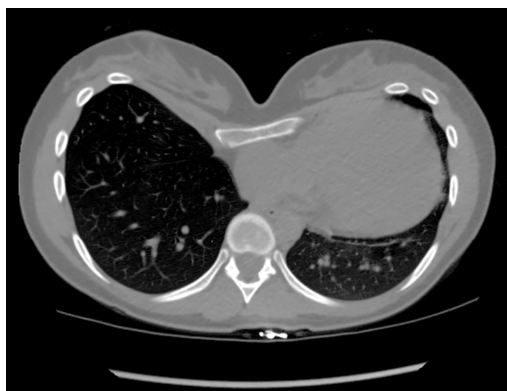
CT chest without contrast of a 24-year-old female patient with pectus excavatum (HI measured at 7.14). Scan shows compression of the right side of the heart (right atrium and ventricle) with displacement of the heart to the left side. CT, computerized tomography; HI, Haller index.
